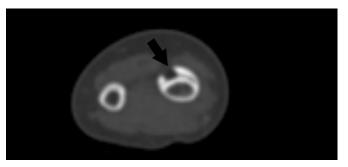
CT appearance of the posttraumatic cystic bone lesion. A well-circumscribed cortical lesion with fatty density (arrow) is seen.
